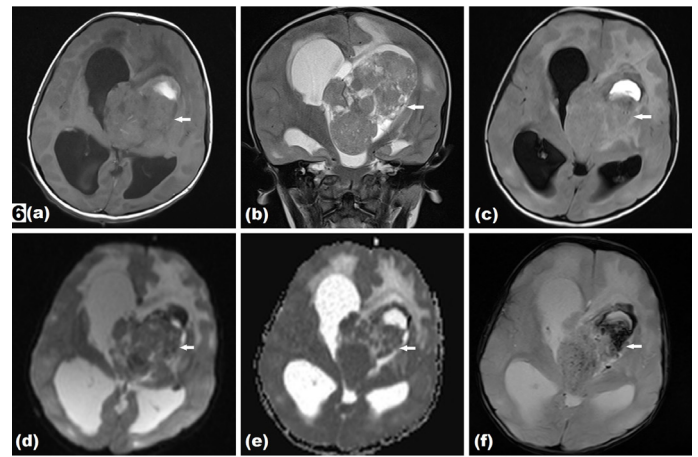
MRI of fatal case of choroid plexus tumor (arrow) in a 4-year-old patient. (a) axial T1WI showing isointense intraventricular lesion with focal hyperintense foci of bleed. (b-c) T2WI coronal and axial FLAIR images showing relatively isointense lesion with oedema in the adjacent brain parenchyma. (d-e) Diffusion and ADC map showing patchy areas of restriction. (f) GRE image showing blooming of the bleeding foci.
